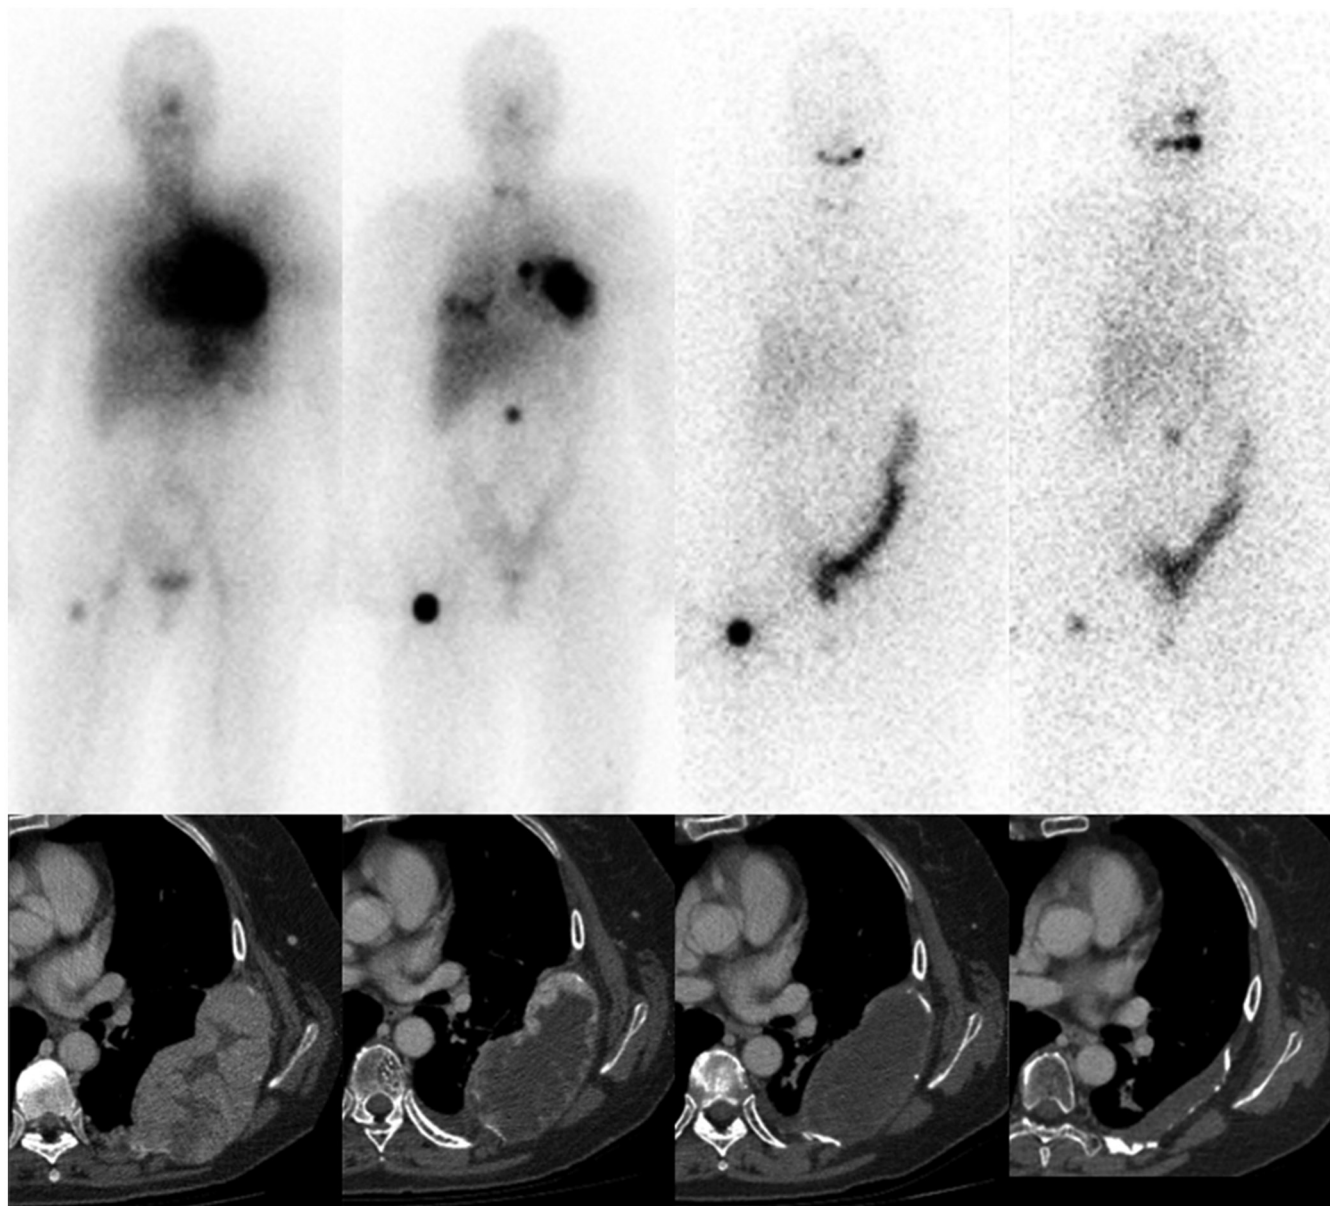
Example of ^{131}I imaging and therapy. A 55-year-old woman with follicular thyroid carcinoma pT3R1NxM1 with skeletal and pulmonary metastases. Total thyroidectomy and laminectomy with fixation of C7 was performed, followed by external beam radiotherapy of a metastasis in the sixth left rib. Subsequently, multiple therapies with ^{131}I were administered. Successive post-therapy scintigrams and CT scans demonstrate regression of the rib lesion. Also, a metastatic lesion in the right femur is visible, which demonstrates only minimal ^{131}I accumulation at the first therapy, likely due to competition with the extreme ^{131}I uptake in the rib lesion. At the second therapy, the femur lesion showed improved ^{131}I uptake, with clear regression at subsequent post-therapy scans. Thyroglobulin levels decreased from 6112 $\mu\text{g}/\text{L}$ at first therapy to 58.9 $\mu\text{g}/\text{L}$ at fourth therapy. The scans also show physiological activity in salivary glands, liver, bowels, and bladder. CT, computed tomography; C7, cervical vertebra 7; ^{131}I , iodine-131.
